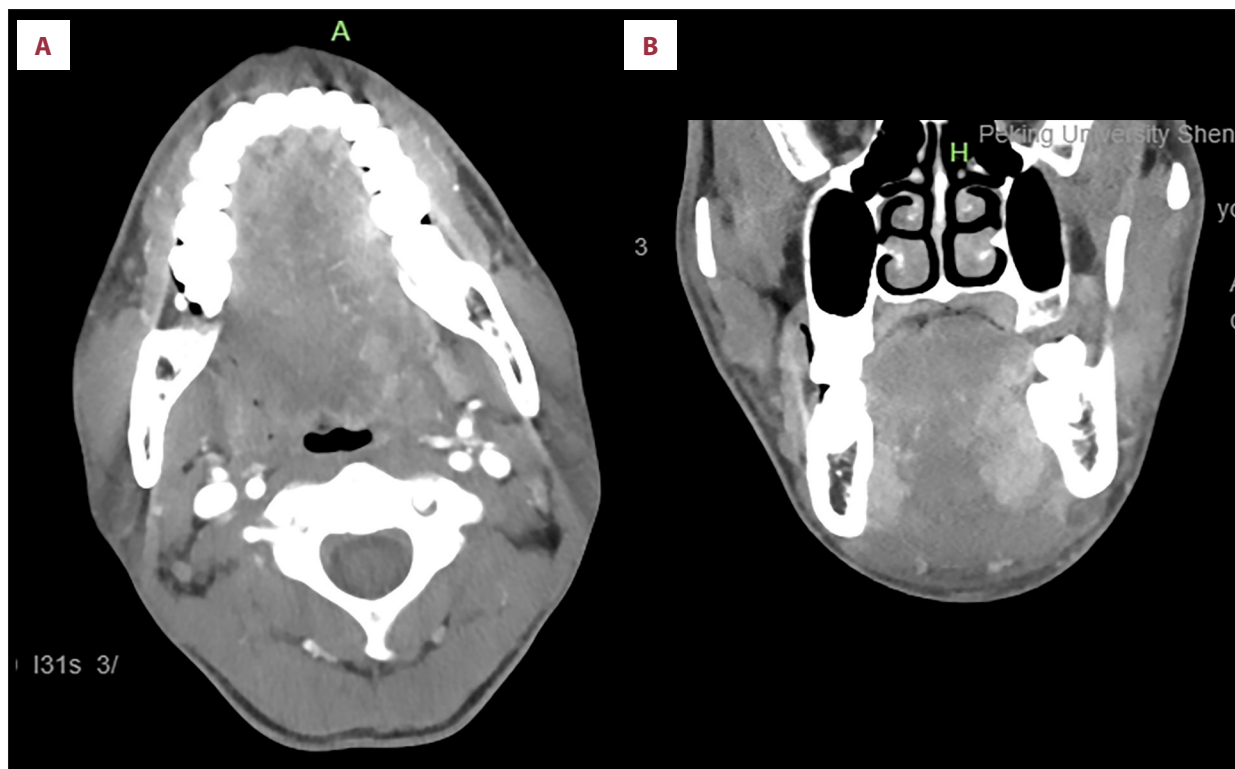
Computed tomography images of the mass. (A) Axial plane of the mass. (B) Coronal plane of the mass.
